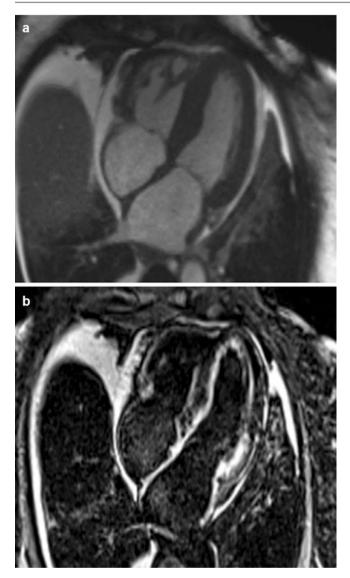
Cardiac MRI of a patient with cardiac amyloidosis. Image (a) shows thickening of the myocardium along with dilated atria. The T1 image (b) shows global subendocardial hyperenhancement which is characteristic of cardiac amyloid
